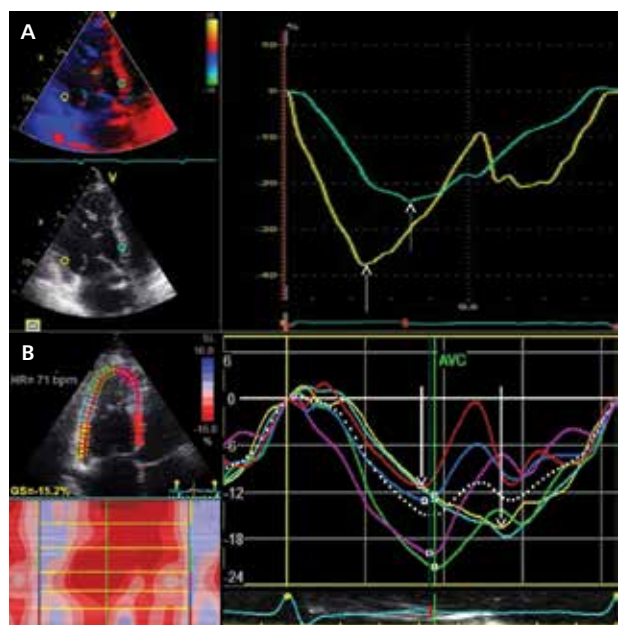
Measurement of the right ventricular (RV) dyssynchrony; A. Tissue Doppler pulsed-wave Doppler algorithm for assessment of RV dyssynchrony based on the difference between time-to-peak strain of the basal segments of inter-ventricular septum (IVS) and free wall of the RV in apical four-chamber view (arrows indicate peak systolic strain); B. Peak systolic longitudinal strain of the RV free wall and IVS obtained with two-dimensional speckle-tracking. The coloured lines represent the time-interval between QRS onset and peak systolic strain for each RV segment for dyssynchrony measurement. Arrows indicate the peak systolic strain of basal lateral (yellow curve) and basal septal (red curve) segments; AVC — aortic valve closure
